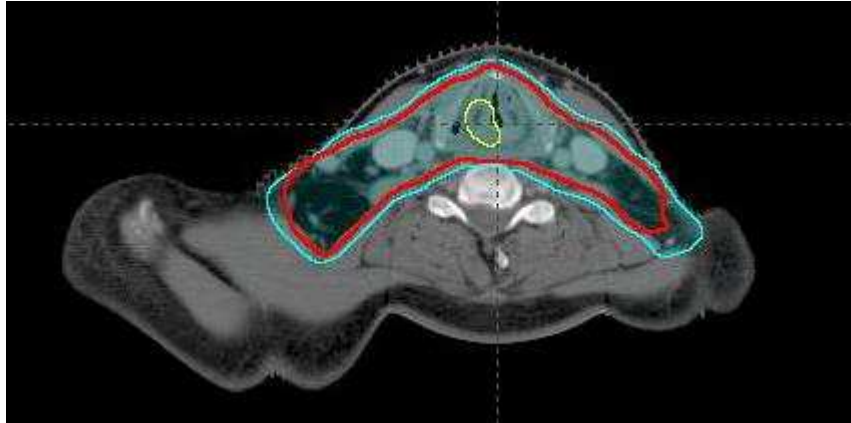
Example of GTV (yellow), CTV (red), and PTV (blue) expansion on an axial CT slice for a case of glottis cancer.
